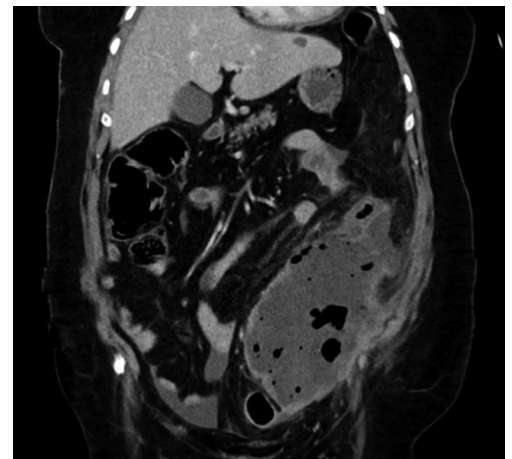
Abdominal CT: retroperitoneal lesion (coronal view).
